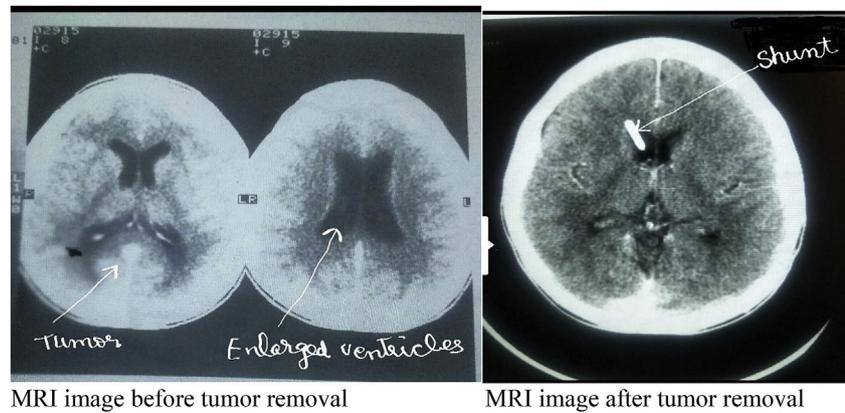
MRI images before and after tumor removal.
